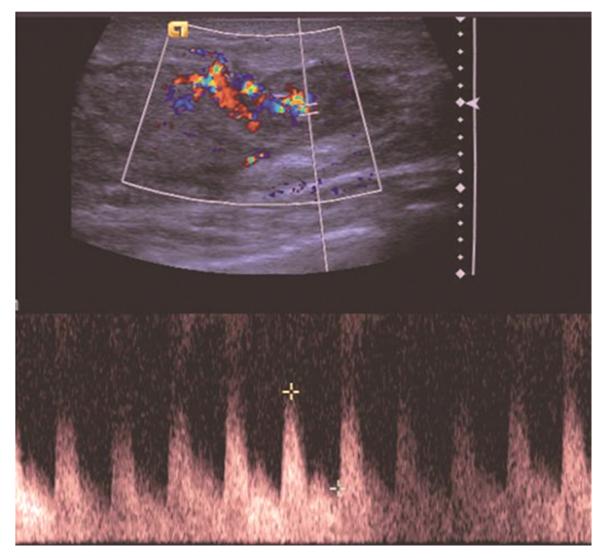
Color Doppler flow imaging (CDFI) of a 48 year-old female with MDE. CDFI indicated abundant blood flow with at least four visible vessels of varied diameter in the view. The RI value was 0.61.
